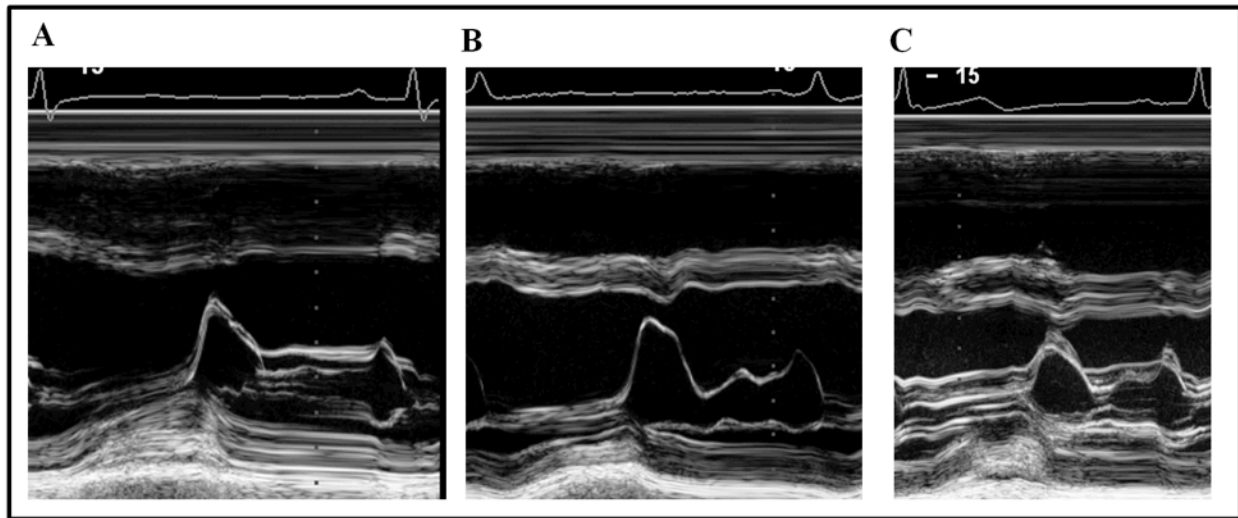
Three types of mitral leaflet motion during diastasis via parasternal M-mode imaging. (A) Mitral leaflets remain coapted during diastasis. (B) Mitral leaflets with a transient separation during diastasis. (C) Mitral leaflets are initially coapted and then transiently separated during diastasis. See text for details.
